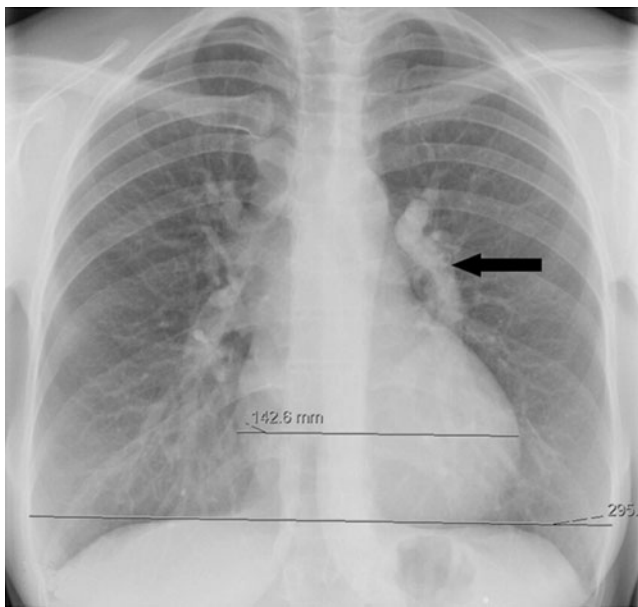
Posteroanterior chest X-ray. *Arrow* indicates the abnormal left pulmonary venous connection
